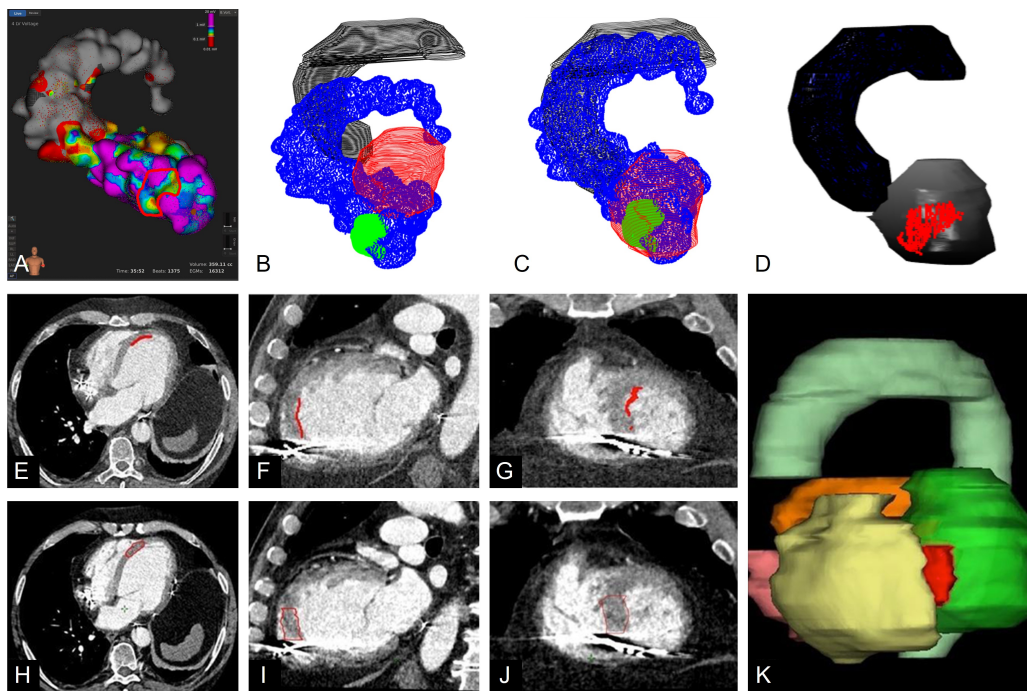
Case 1. (A) Electroanatomical mapping (EAM) data with the marked ventricular tachycardia (VT) target region (red) in anterior-posterior view from RHYTHMIA HDx system. (B) Computed tomography (CT) contours (red: left ventricle, LV; black: aorta) and EAM points (blue: LV and aorta; green: catheter ablation points) before 3D-3D registration. (C) CT contours and EAM points after 3D-3D registration. (D) 3D view of the LV, aorta and 3D-3D registered target points (red). (E-G) Axial, sagittal and coronal views of the cardiac CT with the 3D-3D registered VT target points. (H-J) Axial, sagittal and coronal views of the cardiac CT with the final cardiac clinical target volume (CTV, red). (K) 3D view of the CTV (red) and cardiac substructures (light green: aorta; green: LV; yellow: right ventricle; rose: right atrium; orange: left atrium).
